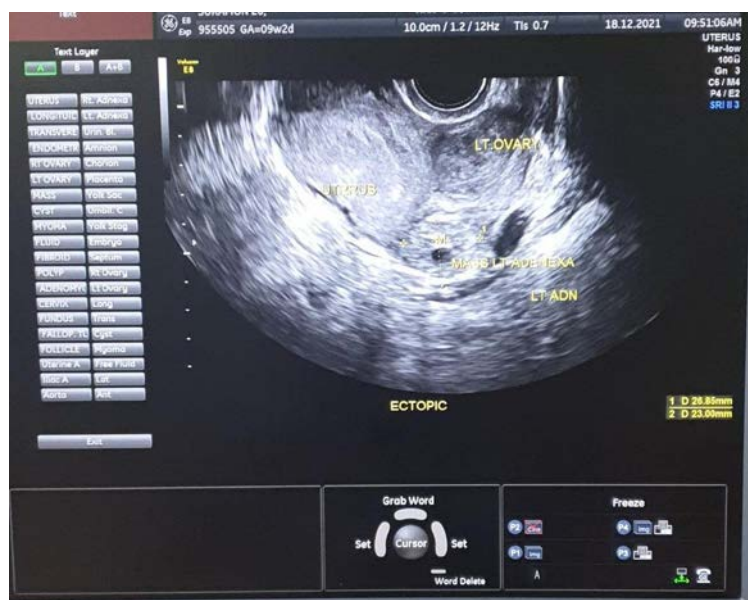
Transvaginal ultrasonography of pelvic region showing ectopic pregnancy.
